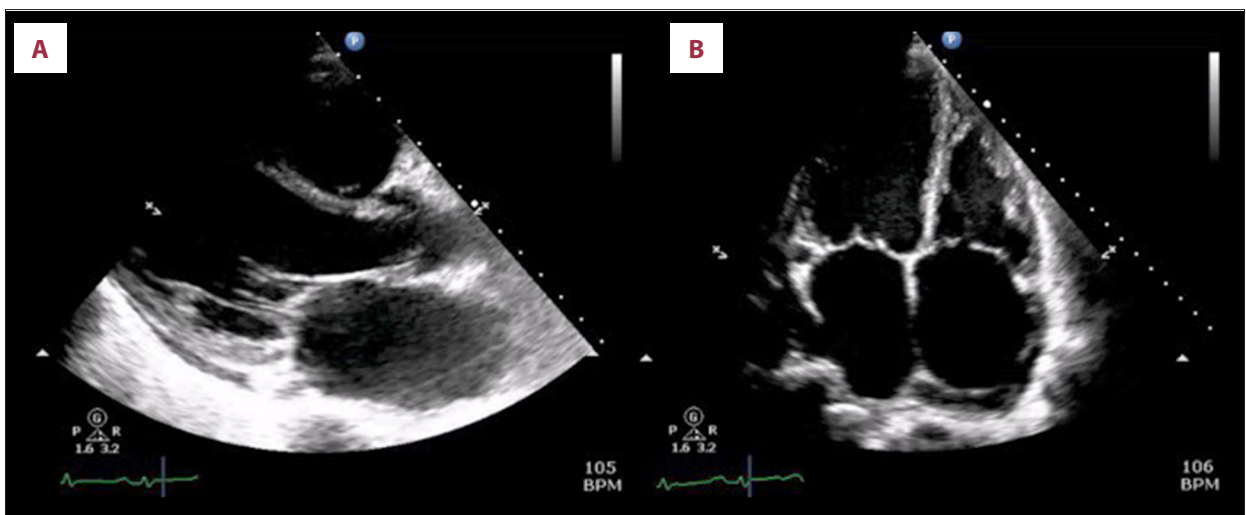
(A) Parasternal long-axis view of transthoracic echocardiography. (B) Four-chamber apical view of transthoracic echocardiography. Both show a dilated left ventricle with severely reduced systolic function and bilateral atrial enlargement.
